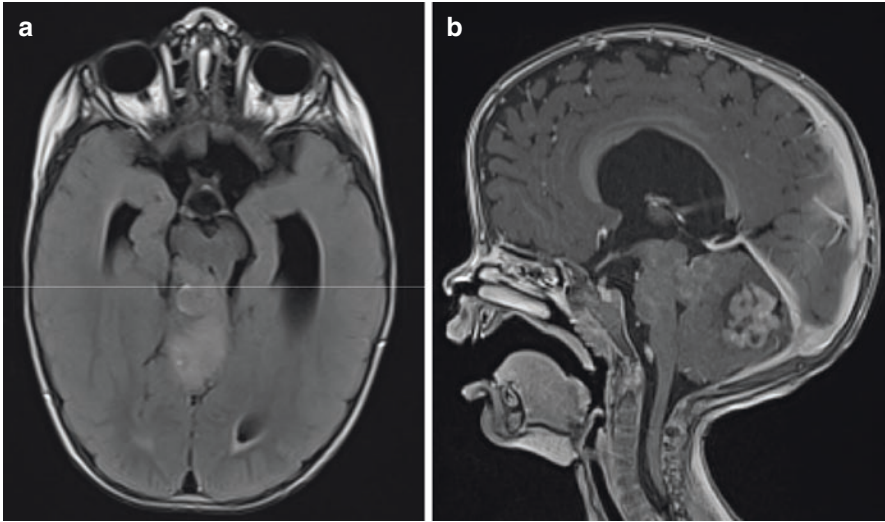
Dorsal Exophytic Brainstem Tumor. (a) Axial FLAIR MRI demonstrating high signal extending from right posterior midbrain into the cerebellum. (b) Sagittal T1 weighted MRI with contrast enhancement in this exophytic lesion originating from the dorsal pons
